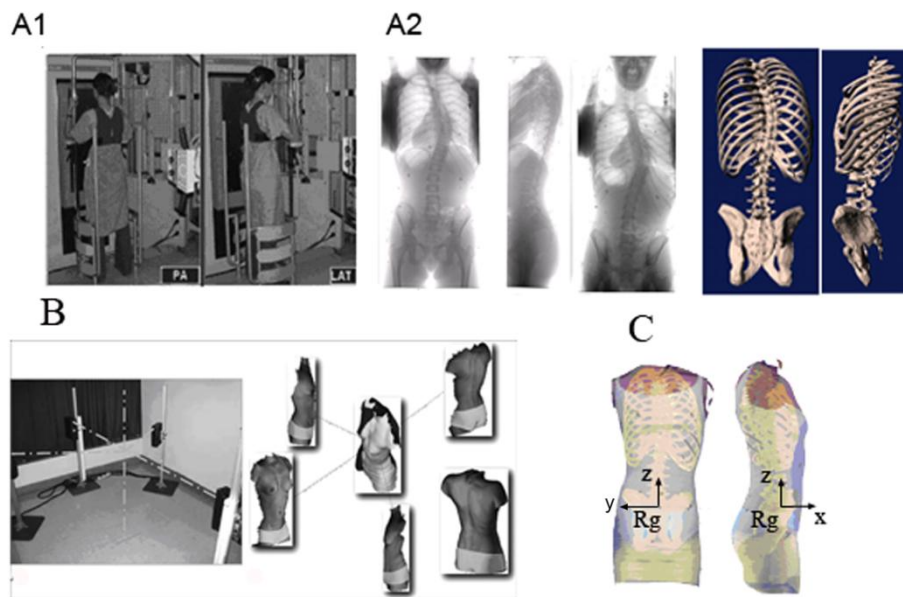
Article 4 Figure 1: A Acquisition of the internal geometry using the multi-view radiographic reconstruction technique: A1- Postero-anterior (PA) and lateral acquisition; A2- PA, lateral, and PA with an incidence of 20° radiographs; A-3 3D reconstruction; B Acquisition of the external geometry using the range sensor topography technique; C Superimposition of the two geometries (Rg: Global reference system).
